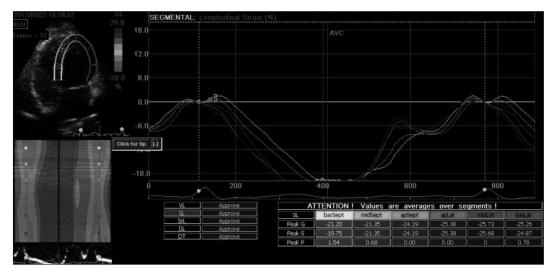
Left ventricular 2D speckle tracking echocardiography pattern in a patient with subclinical hypothyroidism.
